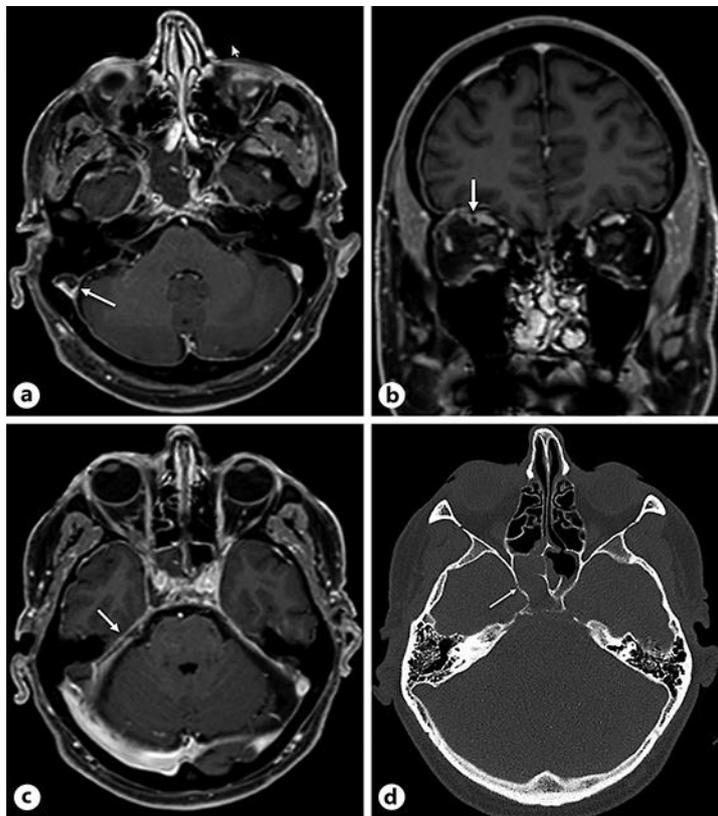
MRI multiplanar reconstruction post-contrast. a Thrombosed sigmoid sinus. b Thrombosed ophthalmic vein. c Thrombosed sphenoparietal sinus. d CT with osseous erosion of the right sphenoid sinus.
